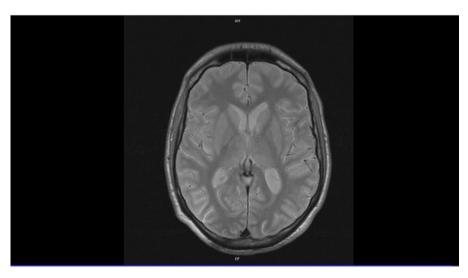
Brain MRI March 2014(b).
